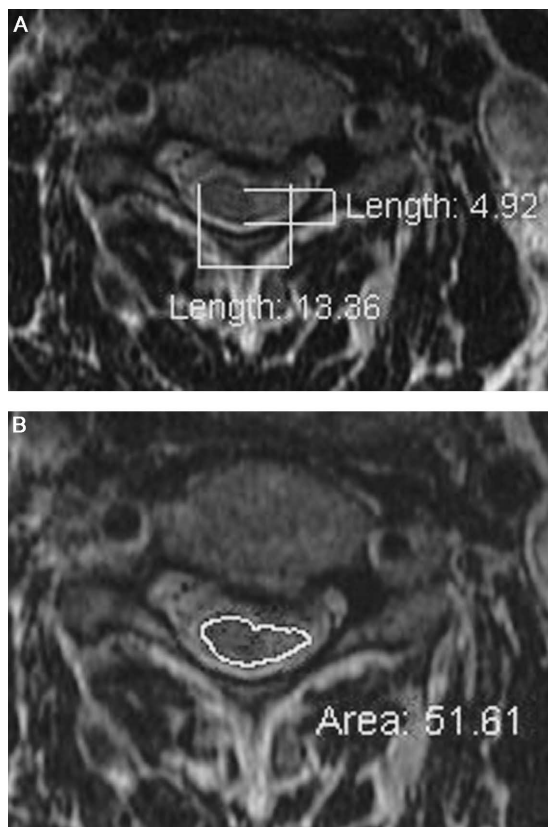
(A) Measurements for the compression ratio using axial T2-weighted MRI. (B) Method of ascertaining the transverse area of spinal cord using axial T2-weighted MRI.
